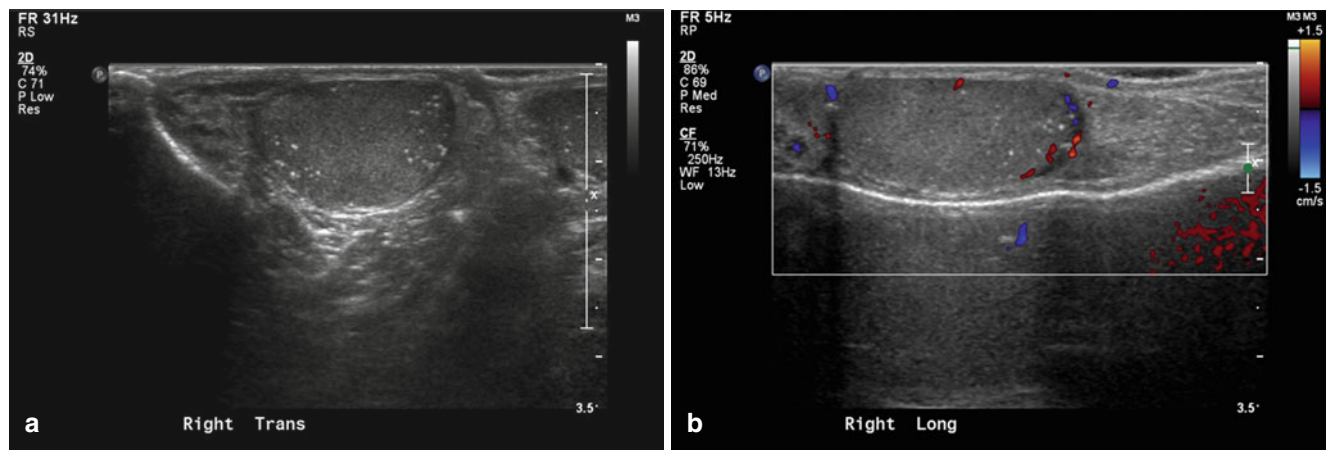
Testicular microlithiasis in a 13-year-old boy. Transverse (a) US and longitudinal color Doppler (b) images of the scrotum demonstrate multiple echogenic foci scattered in the periphery of both testes
